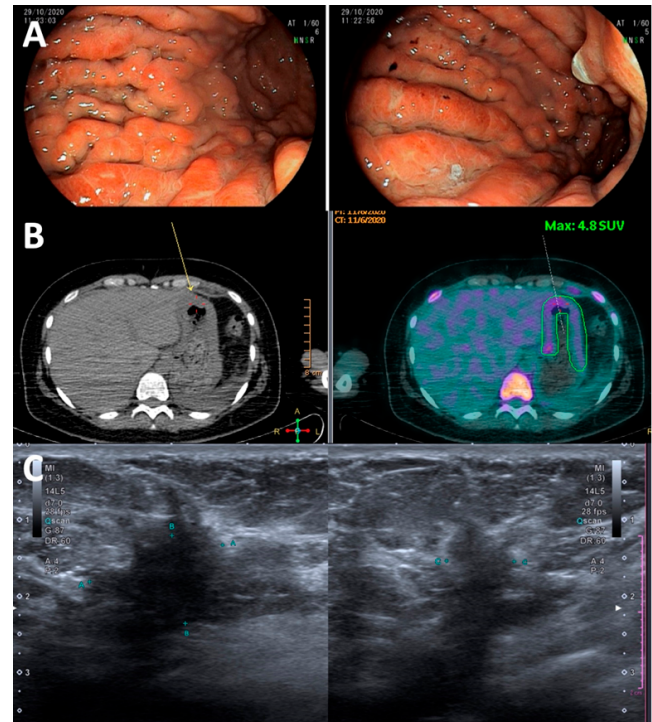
(A) UGI endoscopy showing diffuse thickening and rigidity of the gastric walls. (B) 18F-FDG PET/CT showing uptake along the concentric thickening of the antrum and gastric body. (C) Ultrasound revealing a hypoechoic nodule with irregular shape and indistinct margin in the right breast.
